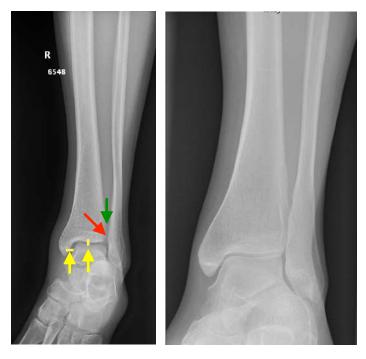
X-Ray image of the left ankle, foot and distal part of the lower leg in a mortise view (preoperative) The X-ray image with an internal rotation of 15 degrees s h o w e d a decreased tibiofibular overlap (indicated with a red arrow), an increased medial clear space (indicated with two yellow arrows) and an increased tibiofibular clear space (indicated with a green arrow).
